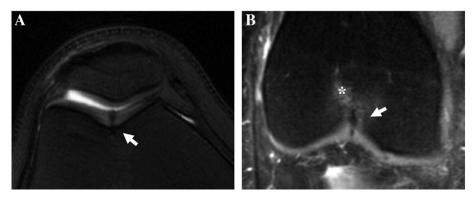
Two cases of the cartilage black line sign (arrows) in the central aspect of the femoral trochlea in (A) a 25-year-old and (B) a 47-year-old woman with knee pain. Subchondral marrow reactive changes are frequently noted with these lesions (asterisk). Sequences are axial (A) and coronal (B) T2-weighted fat-sat (T2FS).
